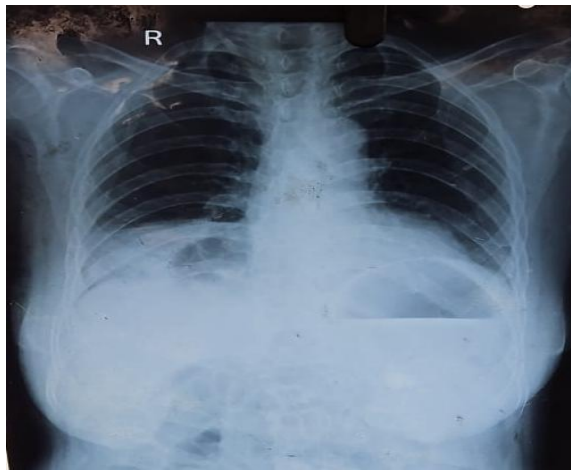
Preoperative Chest X-Ray. The arrow highlights an abnormal shadow over right hemidiaphragm, suggestive of diaphragmatic defect, later confirmed intraoperatively
